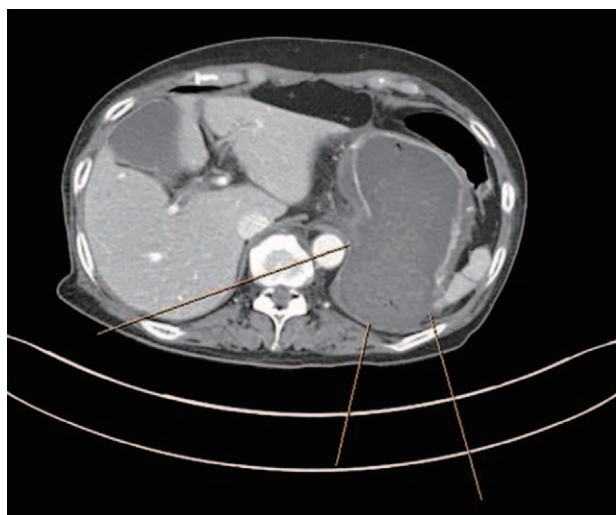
Abdomen computed tomography scans windowed for a defect of the posterior wall of the stomach (between lines).
